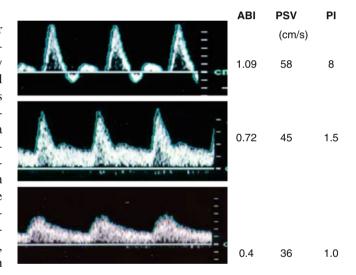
Pulsed Doppler velocity spectra recorded from the posterior tibial artery at the ankle. Note the changes in the velocity spectral waveform (triphasic to monophasic), accompanied by a decrease in peak systolic velocity (PSV) and in pulsatility index (normal: >4), resulting in an overall decrease in ankle-brachial index (ABI) from normal (>0.95) to a level of moderate disease (i.e., claudication) (ABI 0.5-0.9) to critical limb ischemia (ABI ≤0.4)
